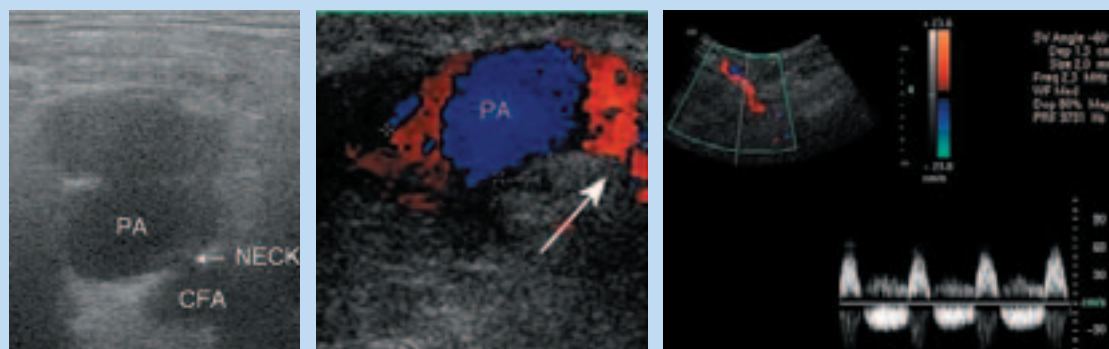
(a) Greyscale ultrasound image of the groin at the level of the common femoral artery (CFA). A bi-lobed pseudoaneurysm (PA) is present. The pseudoaneurysm neck is arrowed. (b) Swirling pattern seen on colour Doppler ultrasound. The pseudoaneurysm neck is arrowed. (c) Spectral Doppler trace from the neck of a pseudoaneurysm. Note the characteristic "to and fro" flow pattern.
